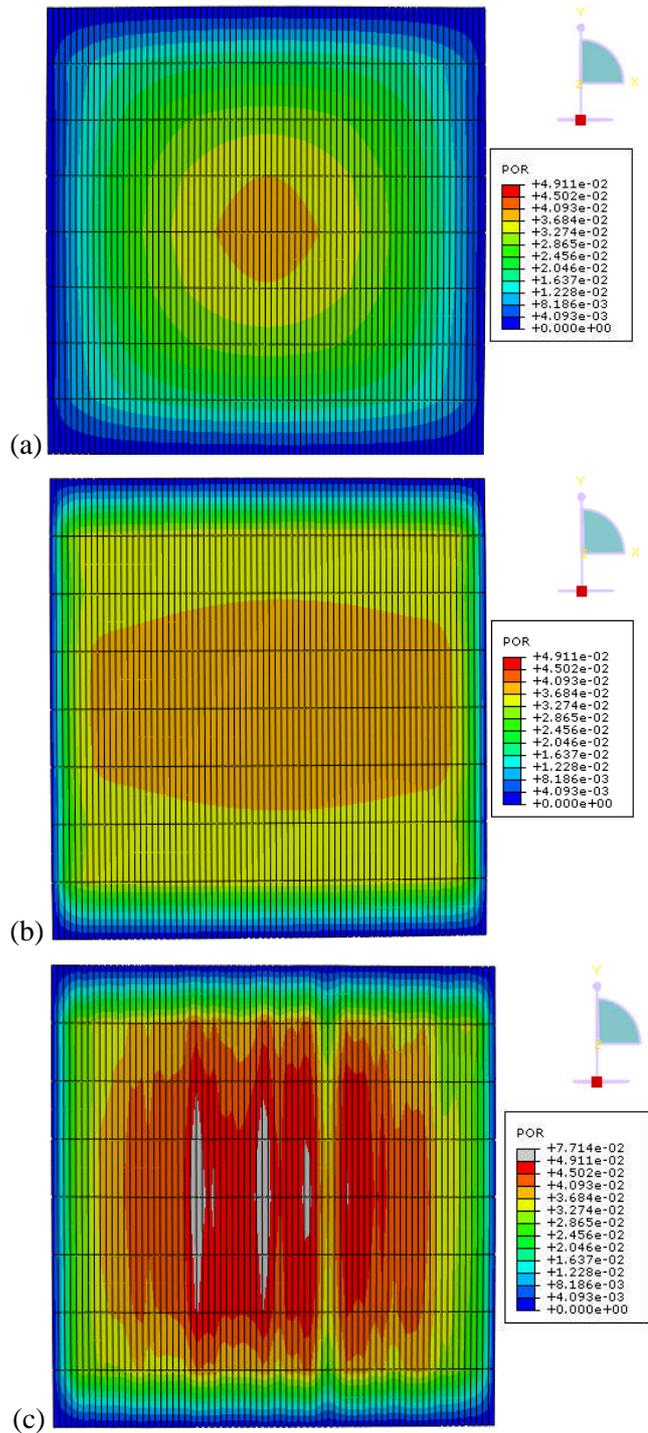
Contour of pore pressure (MPa) on the cartilage surface of (a) the Isotropic-3D, (b) the Uniform-3D and (c) the DT-MRI-3D at the end of ramp loading ($t = 2s$).
